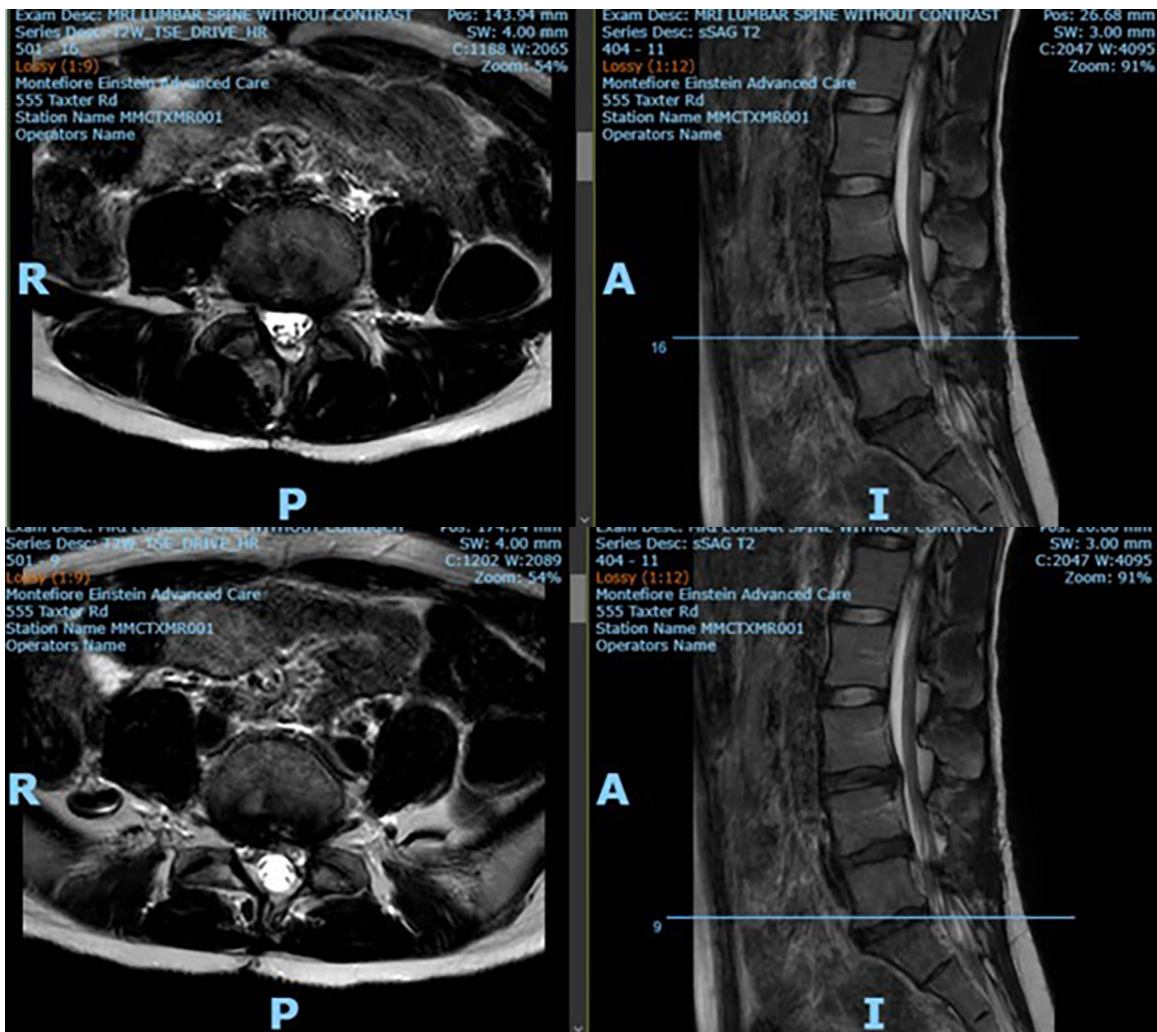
Lumbar MRI from January 2025.
